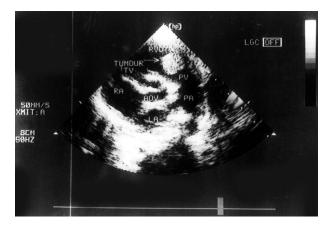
Echocardiography showing an hyperechoic rhabdomyoma.
